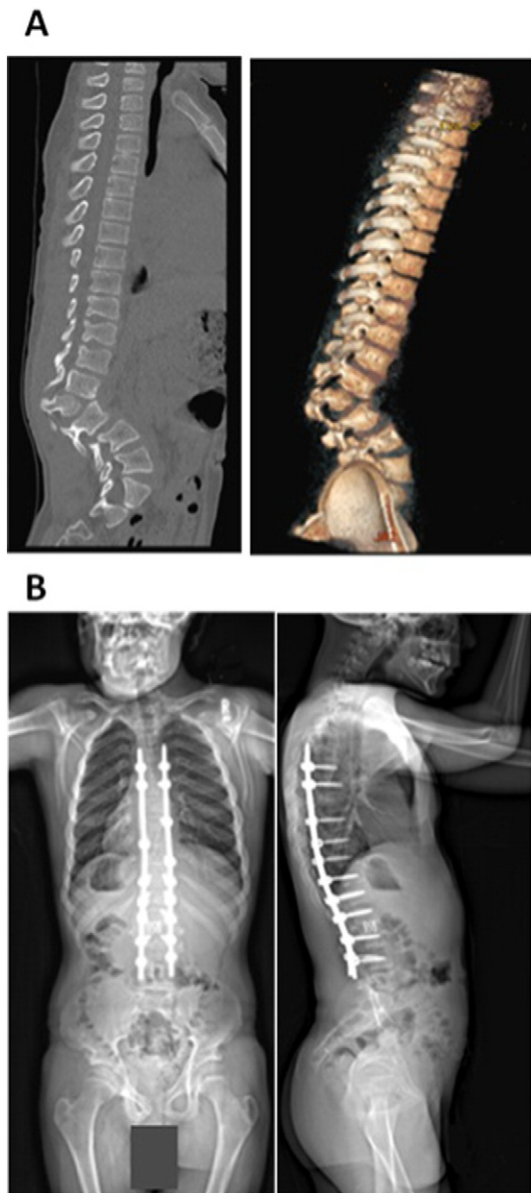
CT for spine and 3D reconstruction at 13 years of age (pre-operation) and X-rays for spine (front and side views) at 14 years of age (post-operation). A) Severe kyphosis of the upper lumbar spine is seen. There is anterolisthesis above and posterior listhesis at the level of the L2 hemivertebra. There are bulging discs at multiple levels with a new rightward disc protrusion at T9–10. Bulging discs in the lumbar region contribute to neuroforaminal stenosis at multiple levels. Extruded disc material is noted anteriorly at the L2 level and also at L4–5 and L3–4. Compression of the nerve roots of the cauda equina due to narrowing of the thecal sac is observed. Mild disc space narrowing at multi-levels in the thoracic spine is observed. B) Spinal rods and disc spacer device appear stable. The iliac crests are at approximately equal heights. The soft tissues appear normal. Rods and pedicle screws appear to be intact. Stable appearance of the thoracolumbar spine is seen following posterior spinal fusion.
